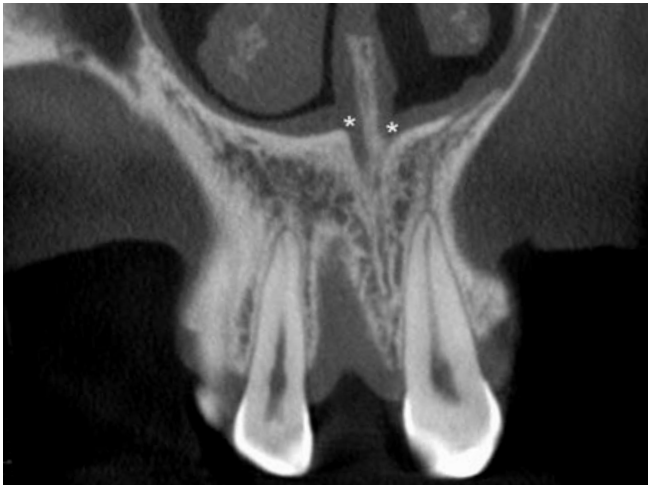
Coronal CBCT slice through the alveolar socket of the missing right central incisor and the neighboring teeth. (*) Nasal openings (foramina of Stenson) of the nasopalatine canal
